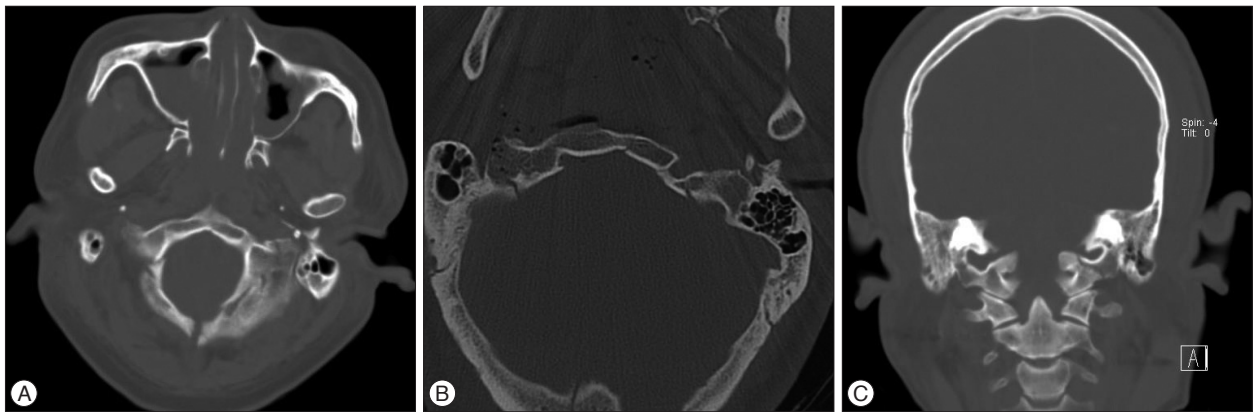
A and B : Skull base computed tomography, with bone windows, reveals a ring fracture involving the clivus, both petrous temporal bones and the posterior part of the foramen magnum. C : Skull base 3-D reconstruction computed tomography reveals no signs of atlanto-occipital dislocation, and the remainder of the cervical spine is intact.
